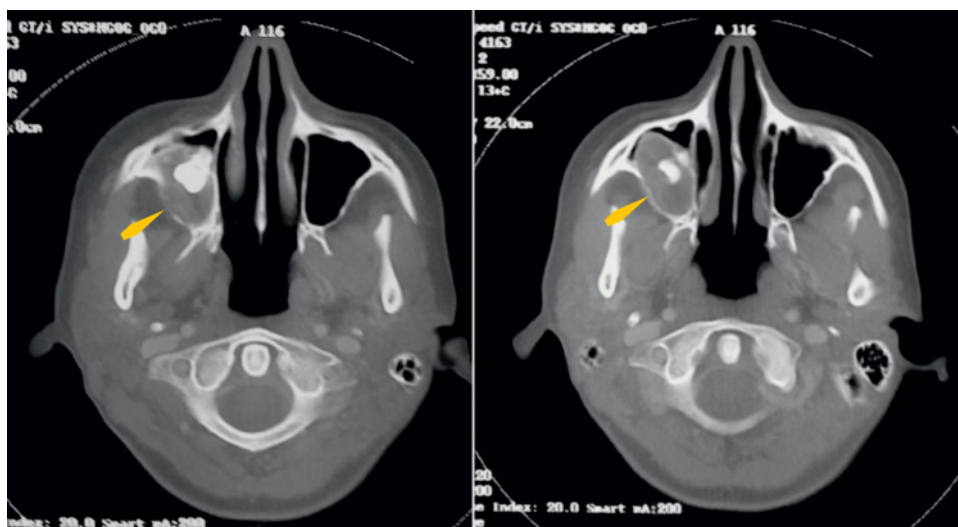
Computed tomography images of an impacted maxillary molar with an associated dentigerous cyst (biopsy showed it to be odontogenic keratocyst). Arrows point to posterior cyst wall with low bone density secondary to infection of the underlying cortical bone.
